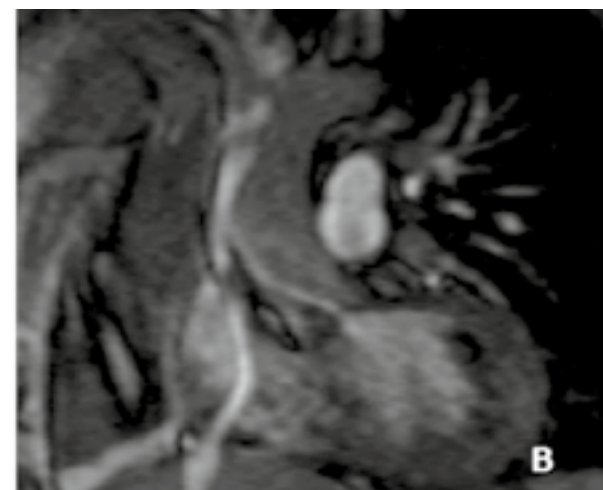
Visualization of the systolic transvalvular flow-jet in cardiac MRI; Eccentric flow-jet directed towards right- posterior segment of the ascending aorta in the oblique sagittal view (A) and coronal view (B)
